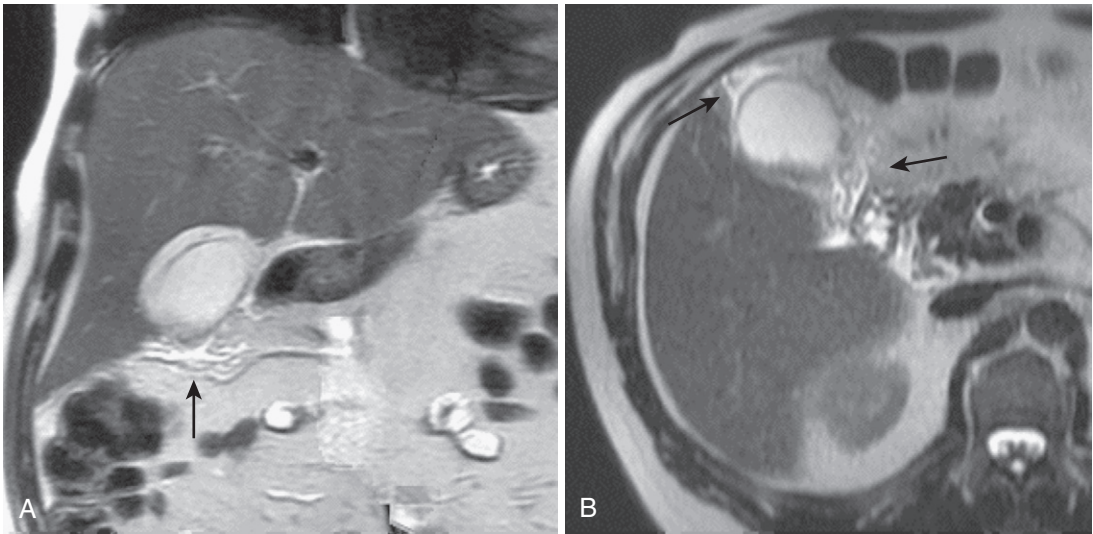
Acute cholecystitis with pericholecystic inflammatory changes. Coronal (A) and axial (B) T2-weighted images in a patient with acute cholecystitis reveal wall thickening, gallstones, and pericholecystic inflammation and fluid (*arrow*).
